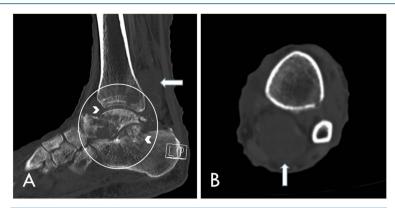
Seventeen days after admission. CT was performed to determine the character and position of the lesion and revealed a pocket-like abscess behind distal tibia (white arrow), multiple osteolytic lesionin his left ankle (white circle) and pathologic fracture of the talus and calcaneus (white arrow head).
